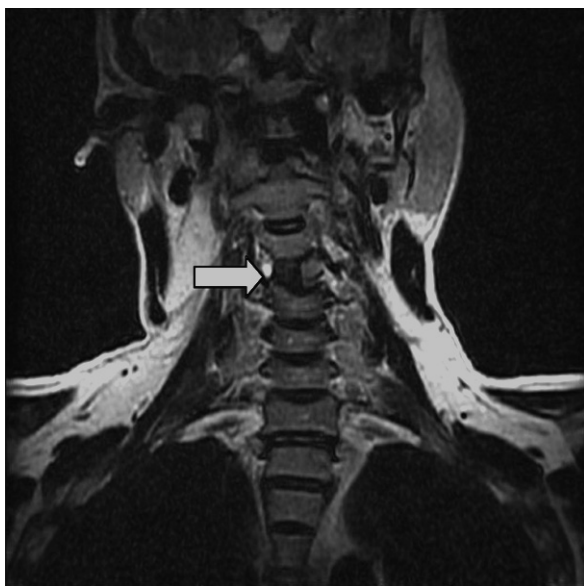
MR image, Fast Relaxation Fast Spin Echo sequence (FRFSE) T2-weighted (coronal). Results of C4 right hemilaminectomy.
